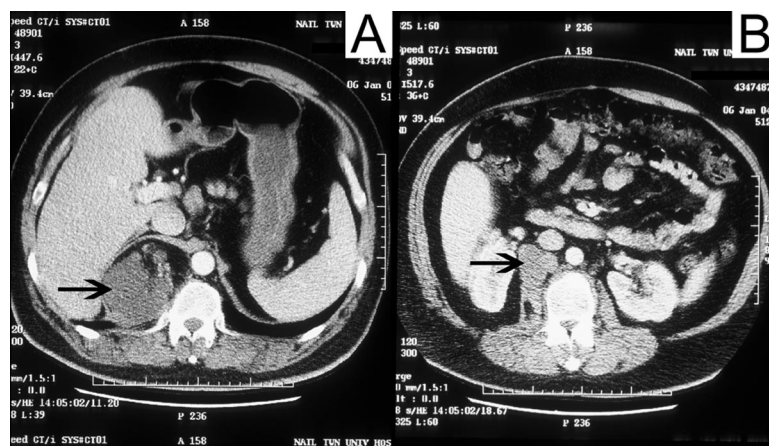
(A) Computed tomographic scan of the chest shows a large lobulated tumor (arrow) in the posterior mediastinum. (B) The tumor (arrow) protrudes through the right diaphragm to the retroperitoneum.
